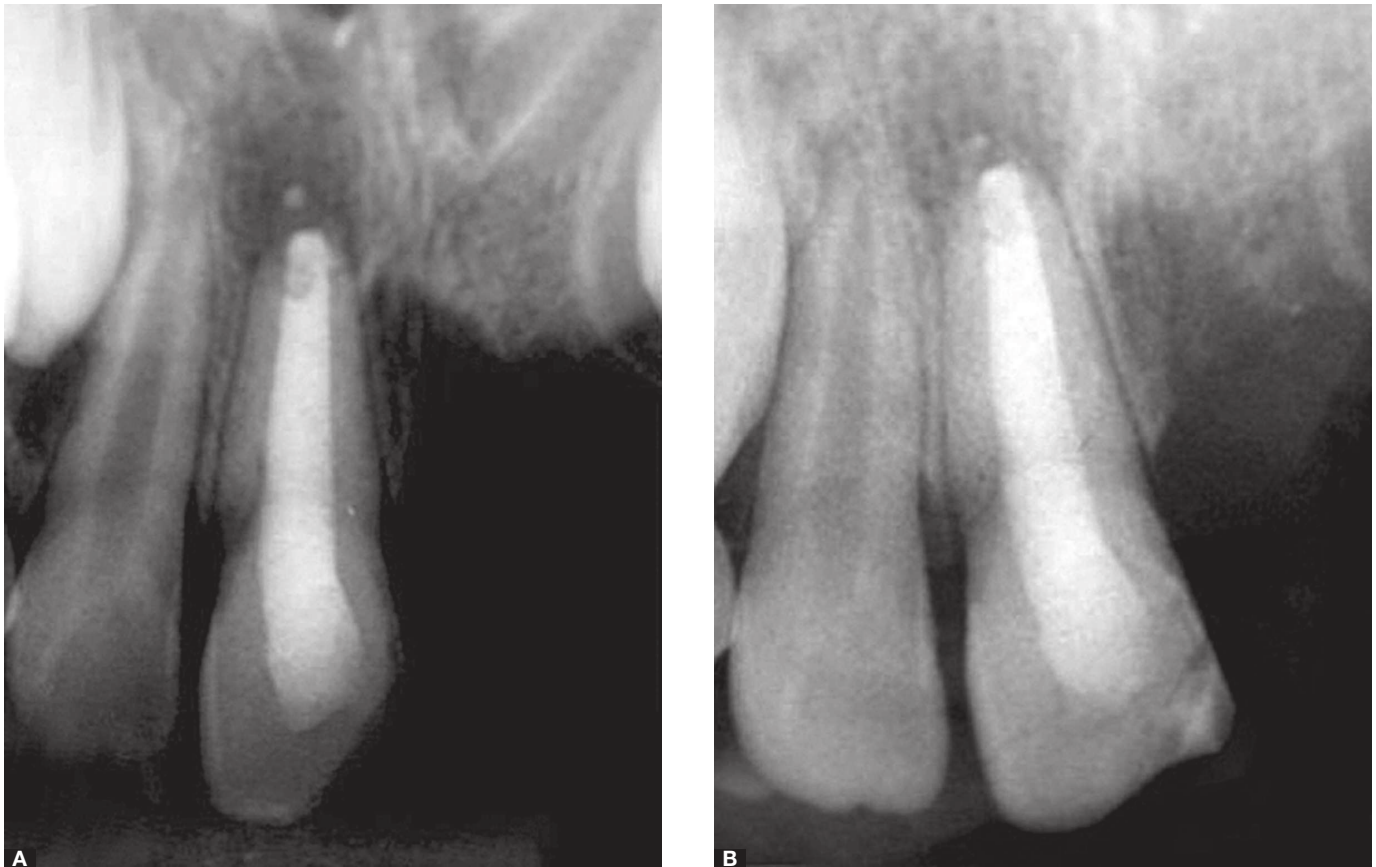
A) Third follow-up radiograph (9 months); B) Eighth follow-up radiograph (2 years).
